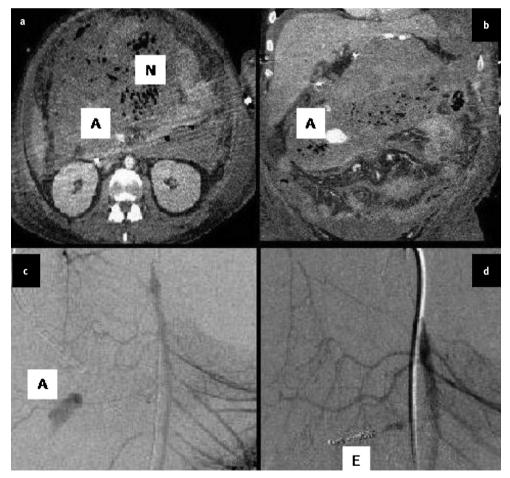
Haemorrhage from a pseudoaneurysm of a branch of the superior mesenteric artery in 44-year-old male with severe acute pancreatitis secondary to alcohol. (a, b) Computed tomography angiographic views (N, necrosis; A, pseudoaneurysm). (c, d) Pre- and post-angiographic embolization views (A, pseudoaneurysm with 'blush'; E, embolization coils with successful sealing).
